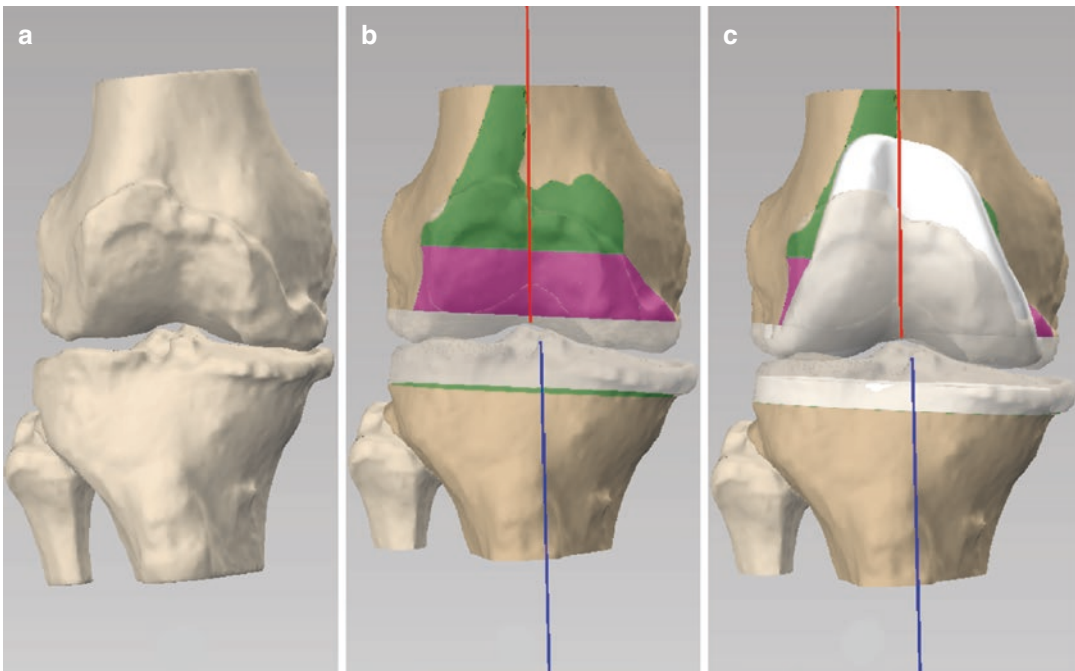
(a–c) The CT-based PSI technique allows a precise reconstruction of the patient’s individual anatomy
